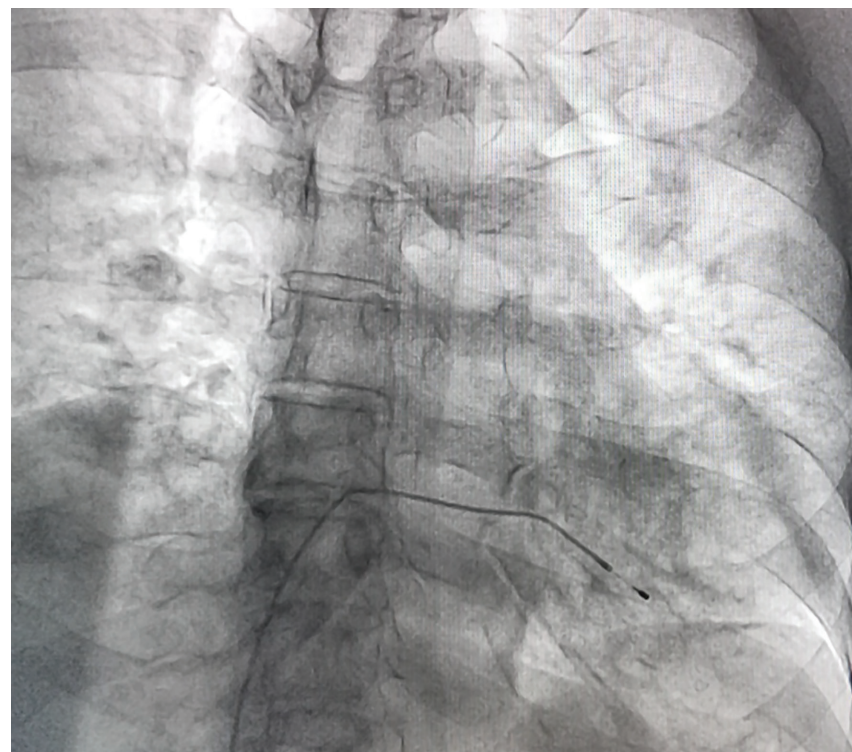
Video 1 (online with the article at [CathLabDigest.com](http://CathLabDigest.com)). A computed tomography scan documented an intra-arterial lead with entry into the right common carotid artery, with the tip crossing the aortic valve and ending in the left ventricular outflow tract.
